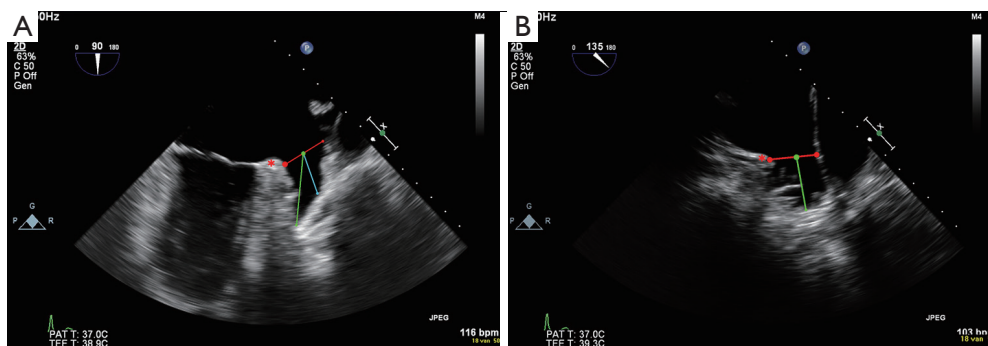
(A) 2D TEE before LAA closure; two-chamber view at 90°; (B) 2D TEE before LAA closure; long-axis view at 135°. Red line: landing zone; green line: LAA total depth; blue line: LAA depth perpendicular to landing zone; red asterix: circumflex coronary artery. TEE, transesophageal echocardiogram; LAA, left atrial appendage.
